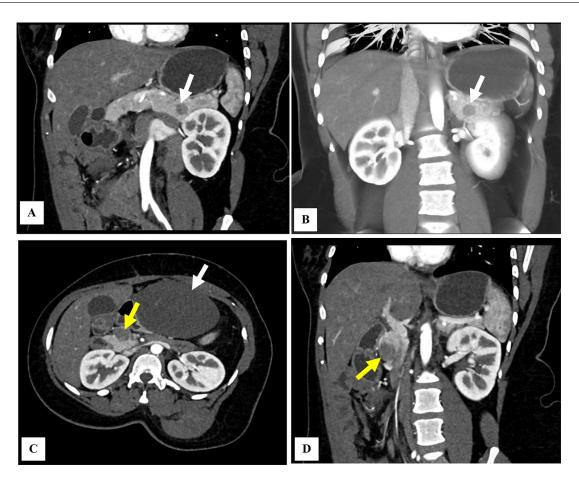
A 33-year-old female with a history of FAP and multiple desmoid tumors. (A and B) Contrast-enhanced CT scans with coronal (A) and volume rendering (B) images showing a mass in the pancreatic tail, approximately 1.4 cm (white arrow). (C) Contrast-enhanced axial CT scan demonstrating a large left abdominal wall mass, likely a desmoid tumor, compressing the bowel loops (white arrow). A lesion is also seen in the pancreatic head (yellow arrow). (D) Coronal CT scan again demonstrating the pancreatic head lesion, approximately 2.3 cm in diameter (yellow arrow).
